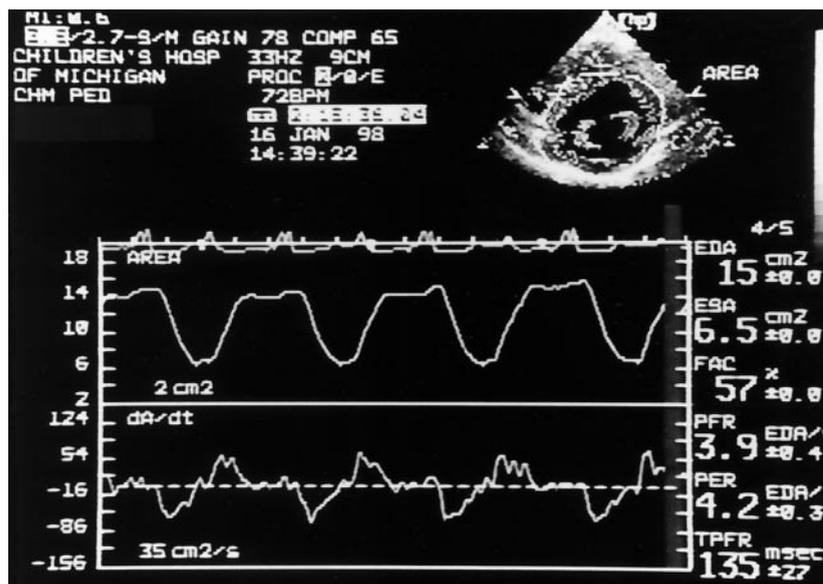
Image of on-line derivation of beat-to-beat changes in the left ventricle area throughout the cardiac cycle, obtained from the parasternal short-axis view using automated border detection by echocardiography. The inherent computer software algorithm allows instantaneous calculation of the fractional area of change (FAC), as well as the maximal rate of rise of LV pressure (+dA/dt) and -dA/dt normalized to the LV end-diastolic area. EDA = end-diastolic area; ESA = end-systolic area; PER = peak emptying rate; PFR = peak filling rate; TPF = time to peak filling rate.
